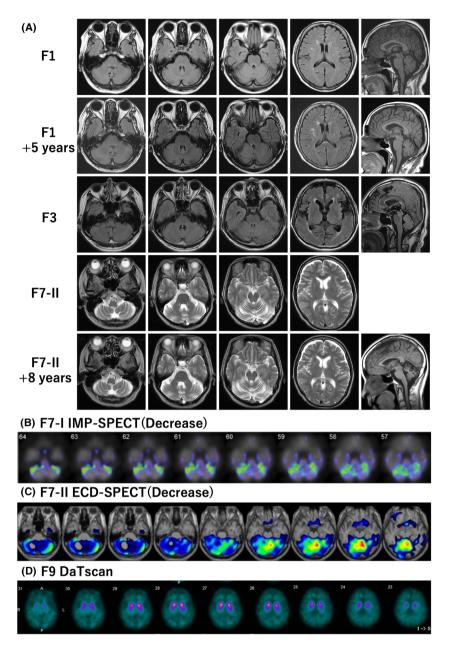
Brain MRI and scintigraphy of patients with *FGF14* GAA repeat expansions. (A) Brain MRI of F1, 3, and 7-II. F1 and F7-II exhibit slight and mild cerebellar atrophy, respectively. While F3 shows no signs of cerebellar atrophy. Brain MRI follow-up indicates minimal longitudinal progression of cerebellar atrophy. Brain MRI follow-up showed minimal longitudinal progression of cerebellar atrophy. (B, C) Isopropyl-piodoamphetamine (IMP)-single-photon emission computed tomography (SPECT) of patient F7-I and ethylene cysteinate dimer (ECD)-SPECT of F7-II. In both patients, hypoperfusion can be observed, specifically limited to the cerebellum. (D) DaTscan (123I-Ioflupane SPECT) of patient F9. A decrease of striatal uptake is evident. All images depicting these radiological findings are available in Figure S1 and S2.
